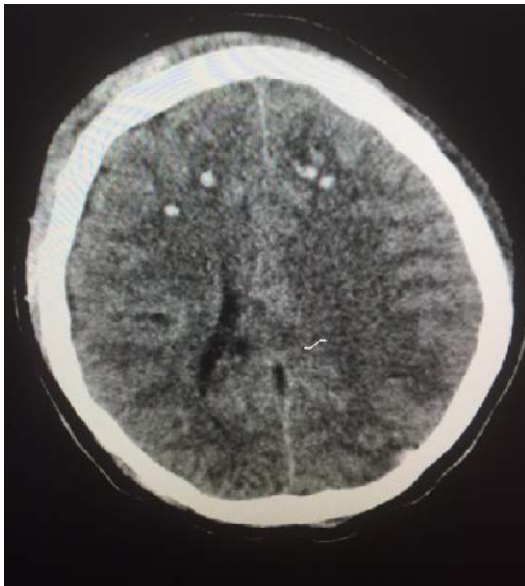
Axial CT image of the brain in brain window showing multiple punctate Hyperdense foci in the grey/white matter junction characteristic of diffuse axonal injury
